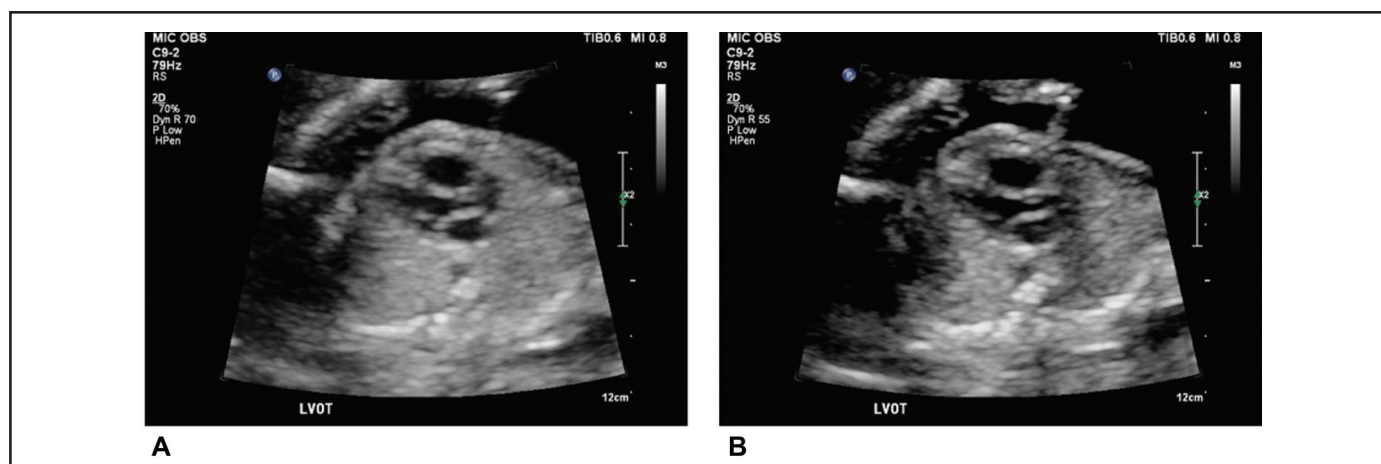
(A) Higher compression setting utilized (dynamic range 70DB), heart structures are not well defined. (B) Optimal compression setting for the fetal heart (dynamic range 55DB) providing a good balance between an optimal resolution of the heart walls and also of the chambers (the actual values of dynamic range will vary between ultrasound systems).<sup>5</sup>
